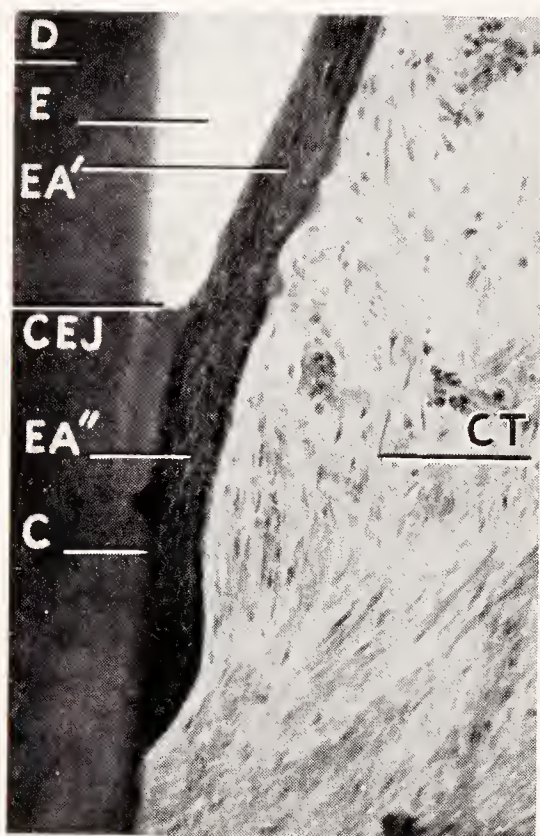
Proliferation of the epithelial attachment along the cementum. *D*, dentin; *E*, enamel space; *C*, cementum; *CEJ*, cemento-enamel junction; *EA'*, epithelial attachment to the enamel; *EA''*, epithelial attachment to the cementum; *CT*, subepithelial connective tissue, free of inflammation.
